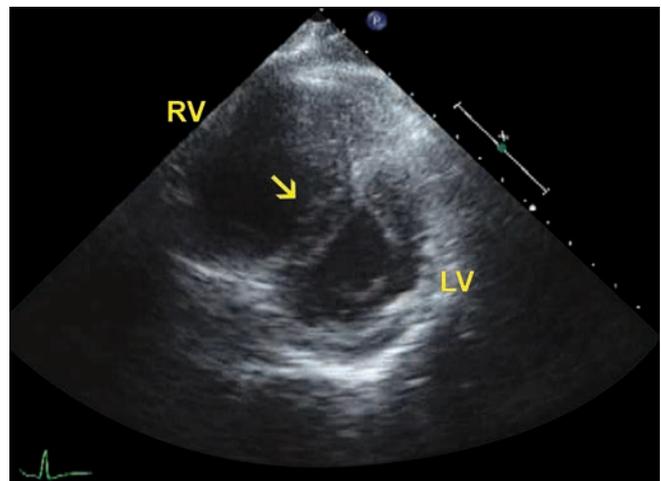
Transthoracic short axis view. Arrow points to flattened interventricular septum.
